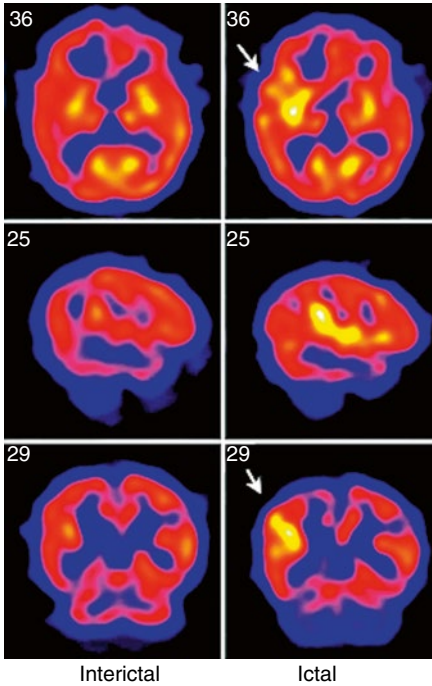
Eight-month-old with intractable seizures. Ictal ^{99m}Tc -ECD SPECT reveals increased brain flow in the epileptogenic zone (arrows)
